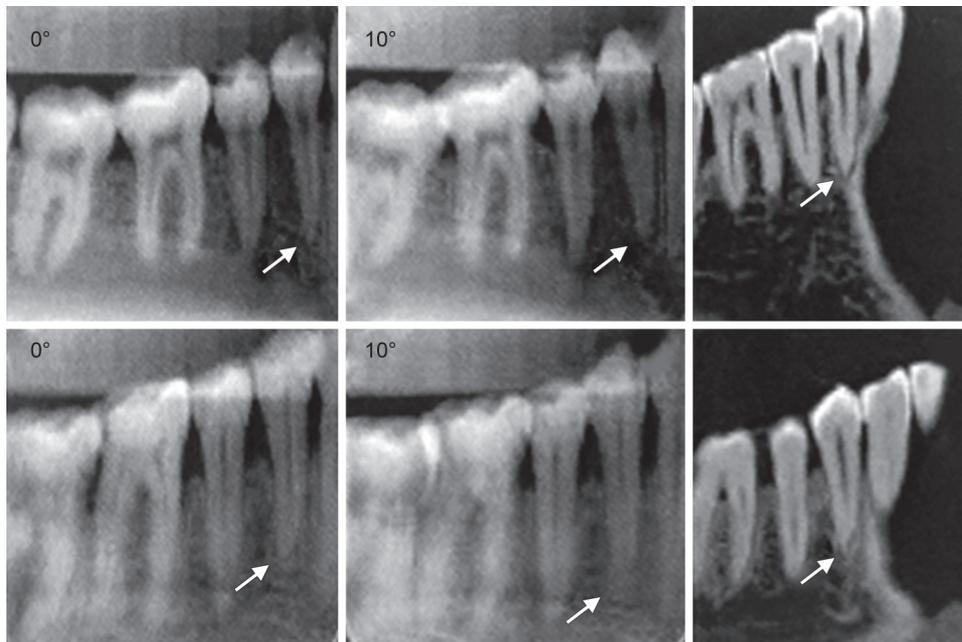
Radiographs evaluated with Scanora software program and its filters
